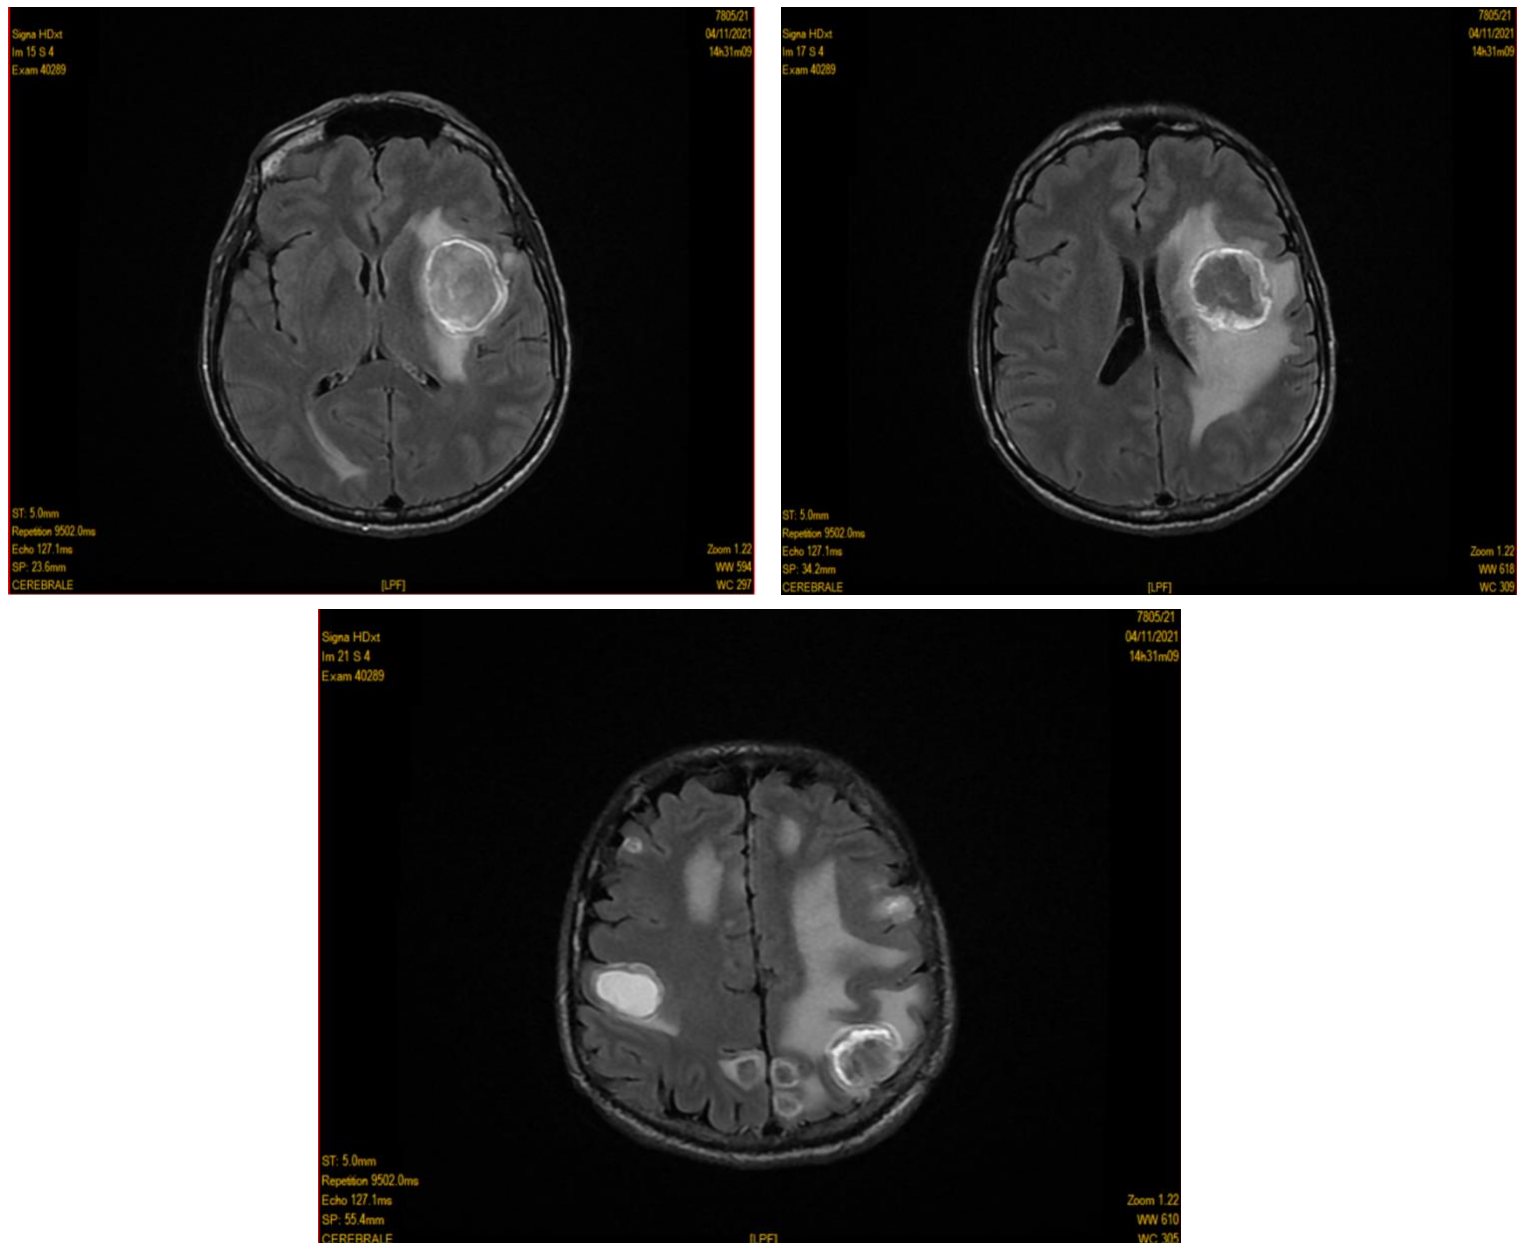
Lesions identified on a brain MRI concurrent with a normal CT scan (
